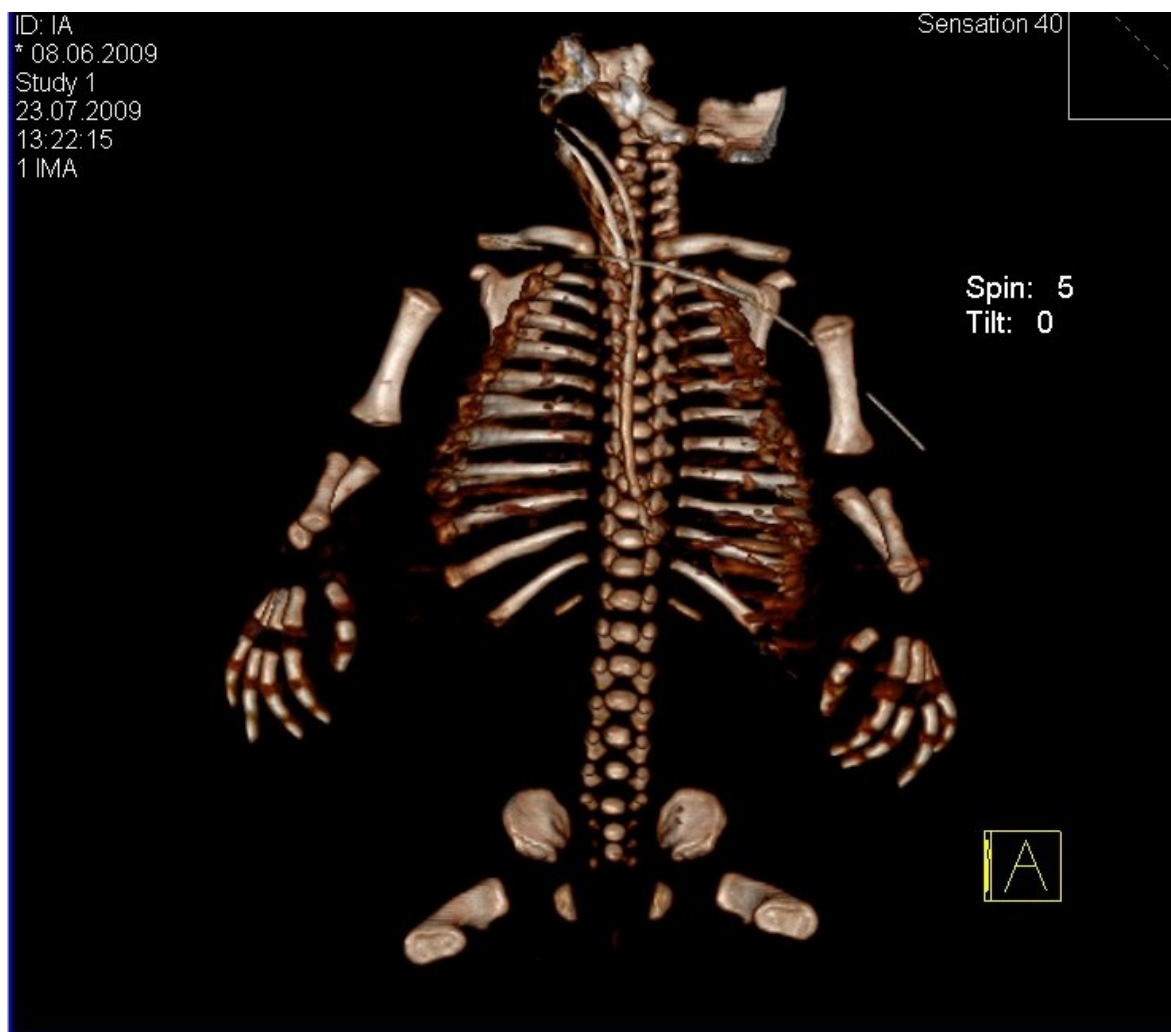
Decreased antero-posterior diameter of chest cavity and shallow acetabular cavity on 3D CT
